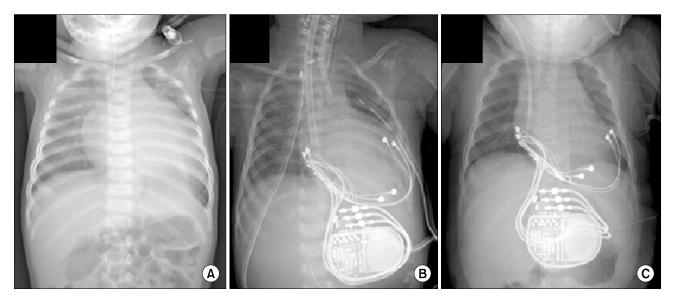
Serial chest radiography showed the improvement of cardiomegaly. (A) At admission. (B) One day after cardiac resynchronization therapy during extracorporeal membrane oxygenation. (C) At 5 months of follow-up.
